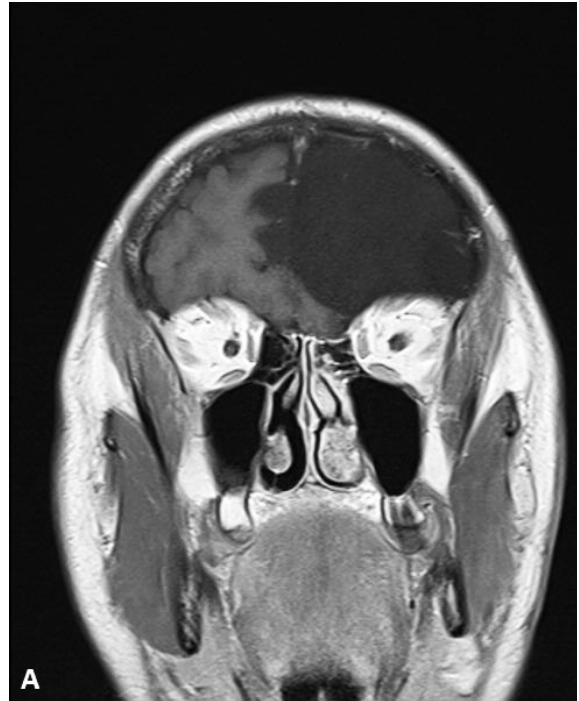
Axial MRI with contrast revealed no enhancement.
